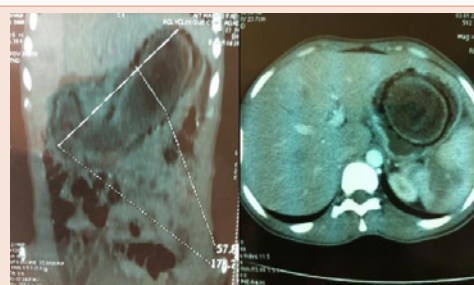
Abdominal CT shows a large heterogenous intraluminal mass occupying almost the entire stomach.
